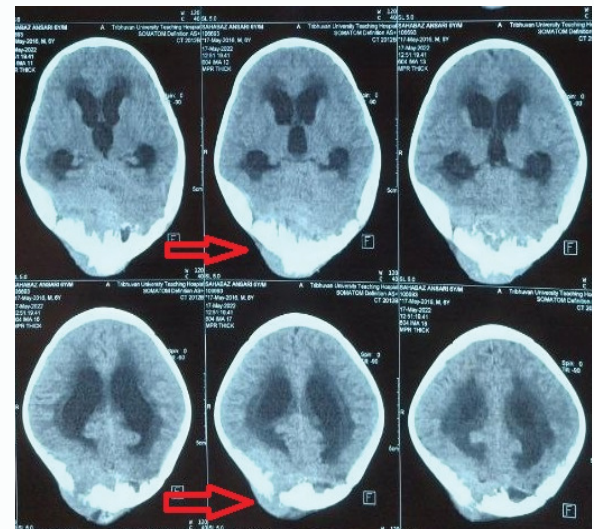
Plain CT head showing mass in the occipital region and non-communicating hydrocephalus.
